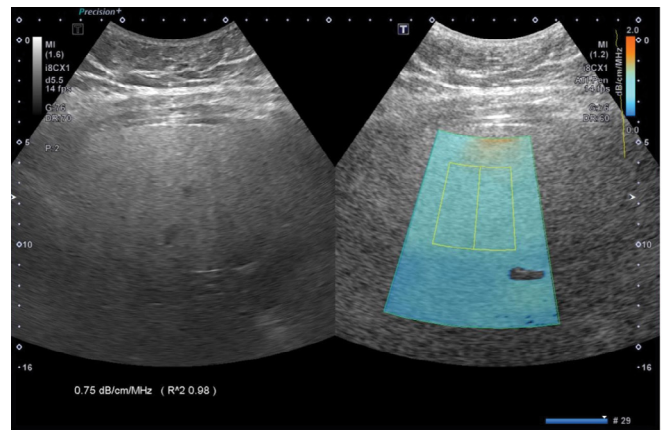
Two-dimensional ultrasound attenuation imaging in a 38-year-old woman. Simultaneous display of B-mode ultrasound image (left) and a color-coded attenuation map (right). A system inherent structure removal filter removes areas of significant errors in attenuation calculation (e.g., large vessels). Coefficient of determination (R^2 value) and attenuation are displayed in each acquisition.
